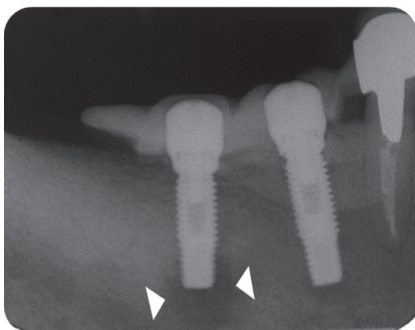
Periapical radiograph at implant 2nd stage surgery which was done after 3 months of 1st surgery. It showed radiolucency at the apex of the implant of the mandibular right first molar area. Arrow heads depict the extent of IPL.
